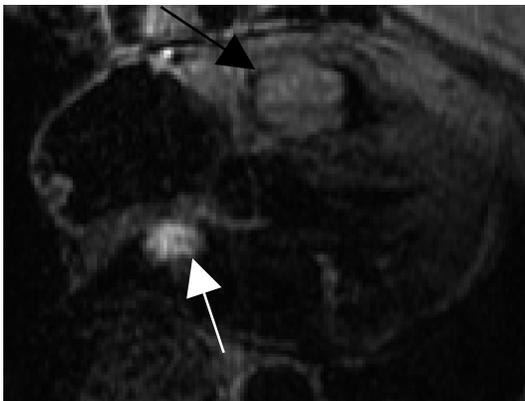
Axial T2-weighted spin echo image. The RVOT mass (dark arrow) shows a significant decrease in signal compared to the T1-weighted images. The left atrial mass (light arrow) conversely is of higher signal than previously.
